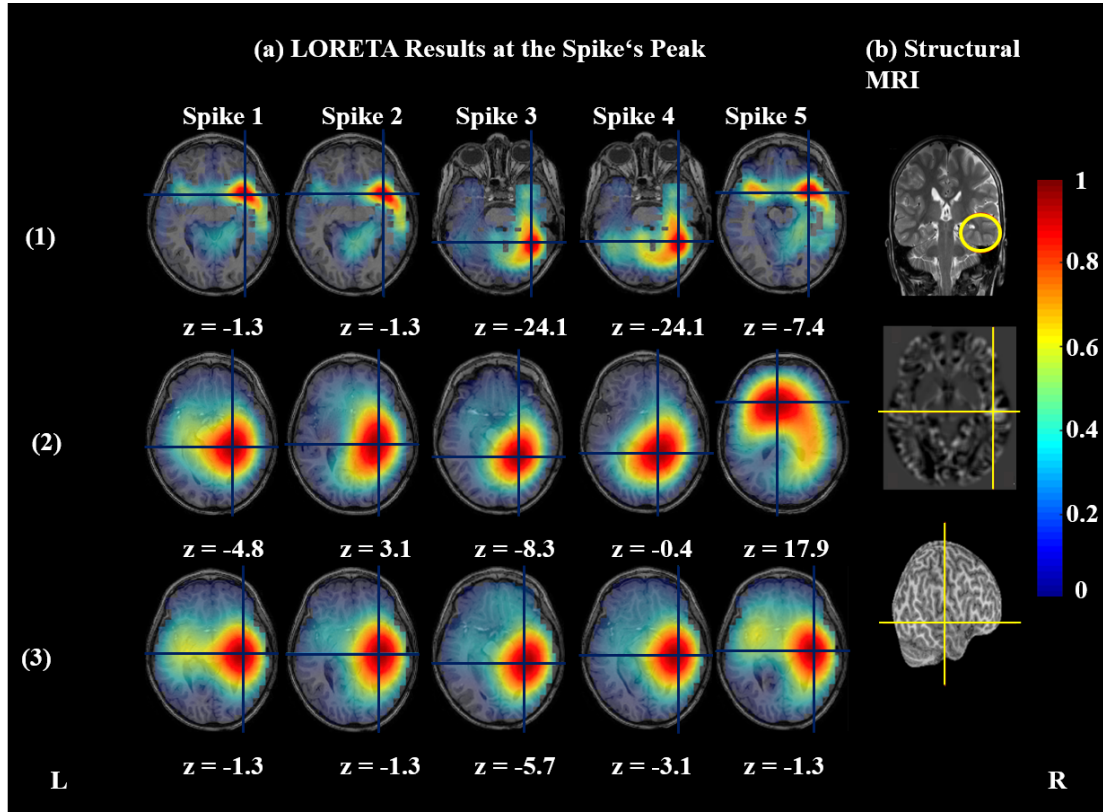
(a) Results of EEG source imaging via LORETA of 5 non-averaged spikes from the EEG recordings of Patient 1. LORETA results using a gray-matter 3D grid and the classical Laplacian matrix are depicted in (1). Results using a full-brain 3D grid and the classical Laplacian matrix are shown in (2). For the results shown in (3), a full-brain grid and the modified Laplacian matrix were used. From left to right the results of Spikes 1-5 are shown in columns 1-5, respectively. The results are visualized as axial MRI slices at each spike's onset, which is defined as 50% of the spike's rise time, and the cursor is placed at the maximum of the estimated current density. Additionally the z-coordinates of the axial slices are shown in Montreal Neurological Institute (MNI) coordinates. In (b) The location and the extent of the FCD on a coronal slice from the patient's preoperative T2-weighted MRI is shown and marked with a yellow circle (top). Additionally in (b), the centers of the yellow cursor mark the detected FCD on an axial slice after morphometric Huppertz MRI analysis [HGF<sup>+</sup>05] (middle) and the FCD on the brain's cortical surface after morphometric Huppertz MRI analysis [HGF<sup>+</sup>05] (bottom). The source imaging results were visualized using the Fieldtrip software [OFMS11]. The figure was adapted from the figures published by the author in [HHJ<sup>+</sup>15]
